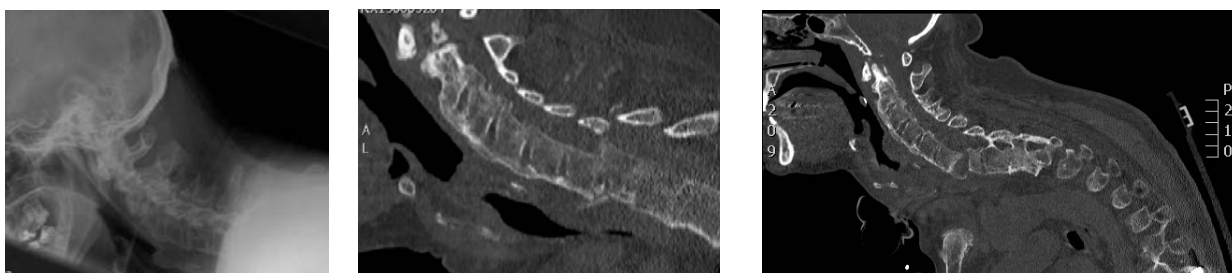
(a): Lateral X-ray of the cervical spine missing C6/C7 level. Fig 1 (b)&(C): CT scan of the cervical spine showed fracture subluxation corresponding with patient's pain and increased cervical kyphotic deformity. .
